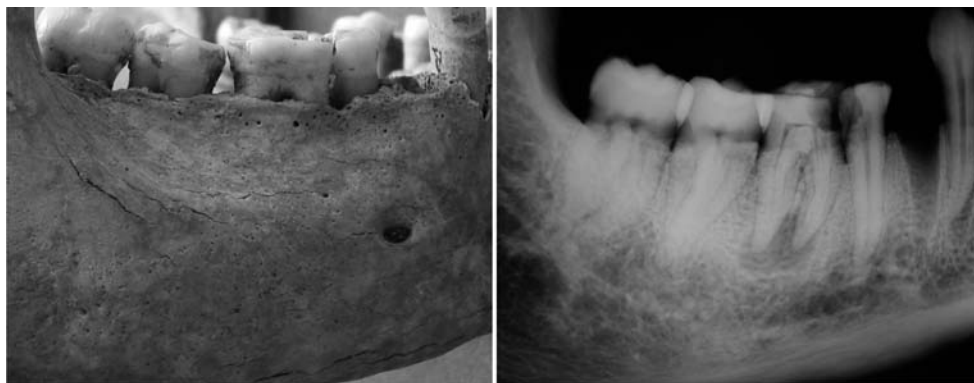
Grossly, this mandible shows no abnormality, but radiography reveals a periapical void at the first molar. This reinforces the importance of radiological examination of well-preserved mandibles
